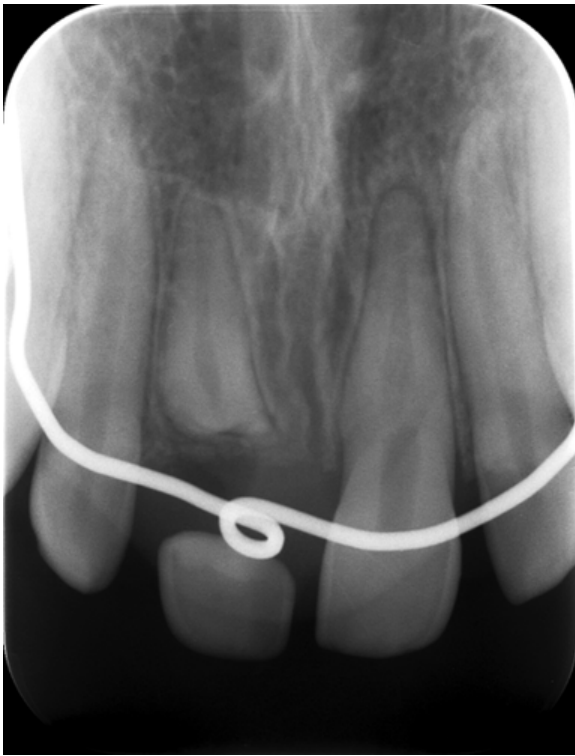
Radiograph of #11 at 5 years
